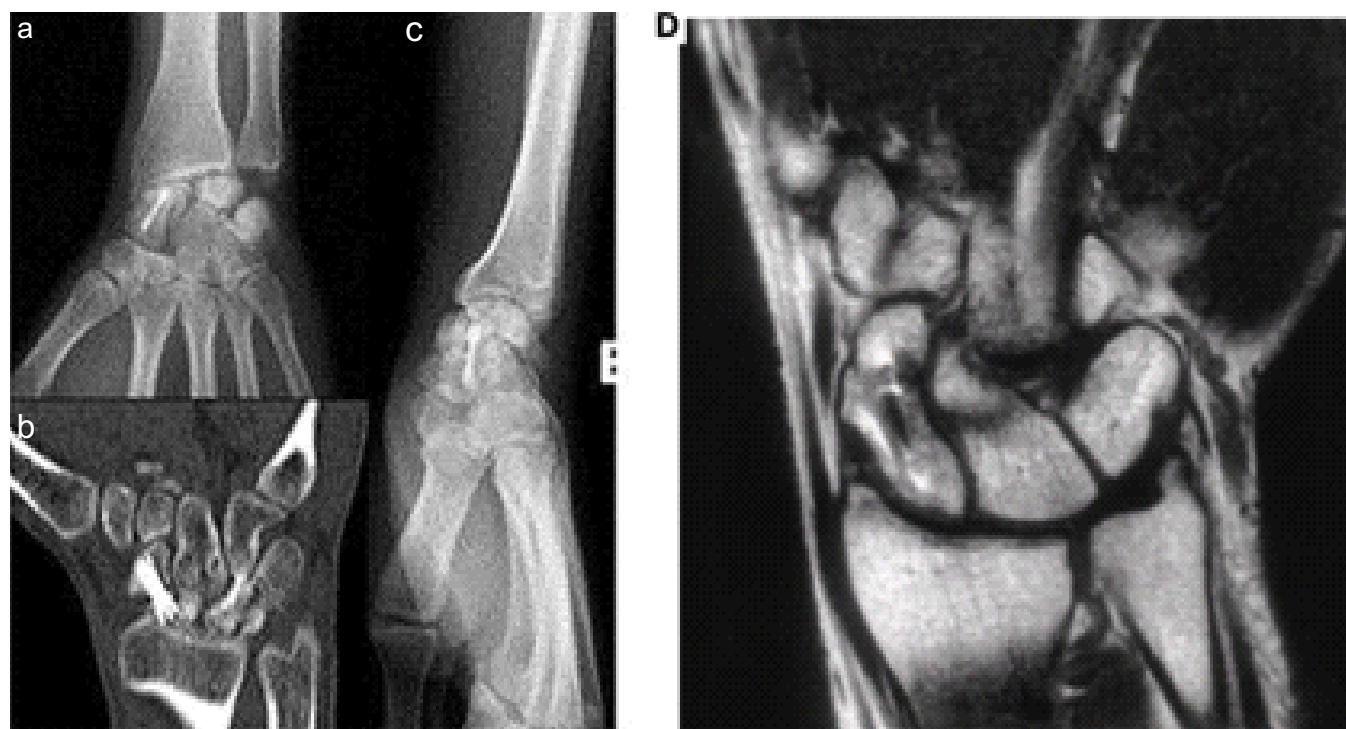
(a) Posteroanterior and (b) lateral X-ray, (c) computed tomography scan, and (d) coronal T2-weighted magnetic resonance imaging of the left wrist 12 months after injury, the latter showing altered marrow signal in the scaphoid and lunate that raised concern for osteonecrosis, without evidence of radiocarpal or midcarpal arthritis.
